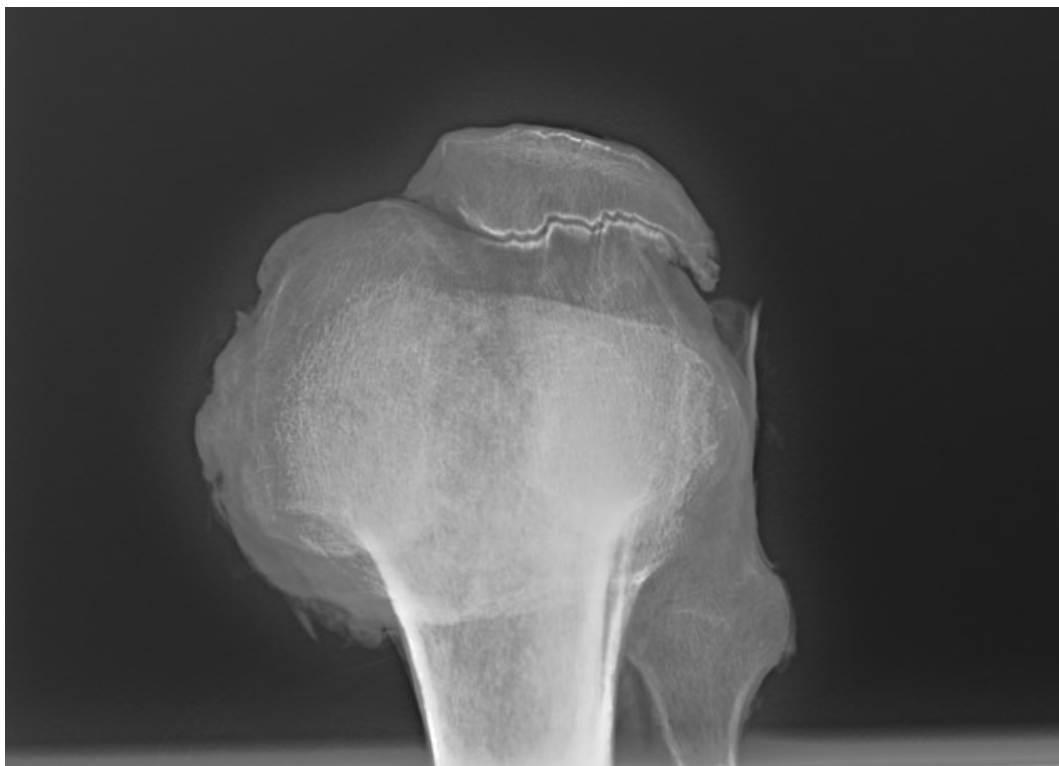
Radiographic image of the left knee displaying the cogwheel grooves observed on the lateral femoral condyle and articular surface of patella.
